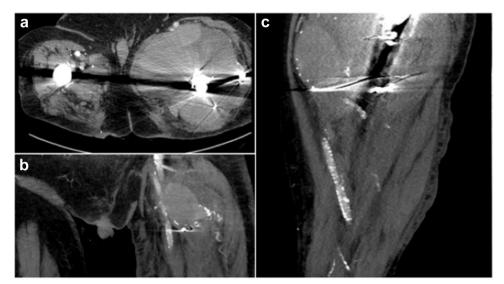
(a)Axial view of the preoperative CT angiogram demonstrating pseudoaneurysm. (b) Coronal view of the preoperative CT angiogram demonstrating pseudoaneurysm. (c) Sagittal view of the preoperative CT angiogram demonstrating pseudoaneurysm.
